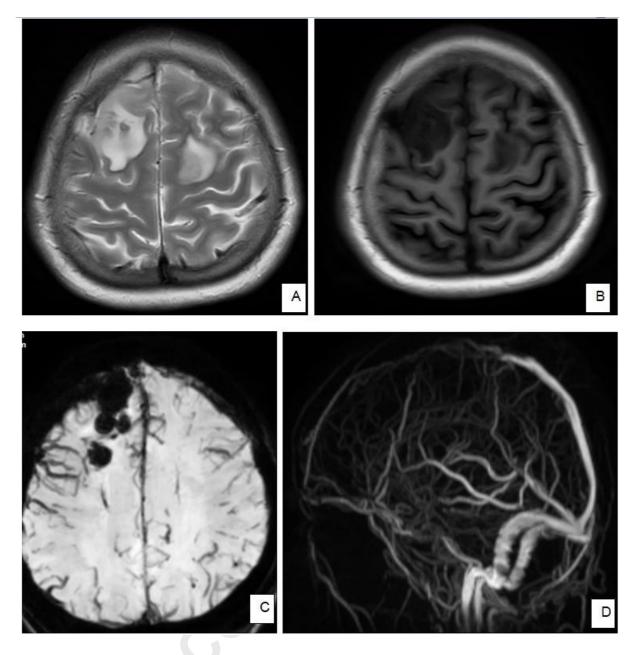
A 21 year old female with COVID-19 infection presented with seizures and fever, underwent MR imaging. Bilateral frontal lobe infarcts with hemorrhagic transformation on the right side was noted secondary to thrombosis of anterior half of superior sagittal sinus. (A) Altered signal intensities in bilateral frontal lobes in the parasagittal location appearing hyperintense on T2,(B) hypointense on T1 with blooming on GRE sequence in the right frontal lobe (C) and absent signal intensity in anterior half of superior sagittal sinus in (D) on 3D TOF-MRV.
